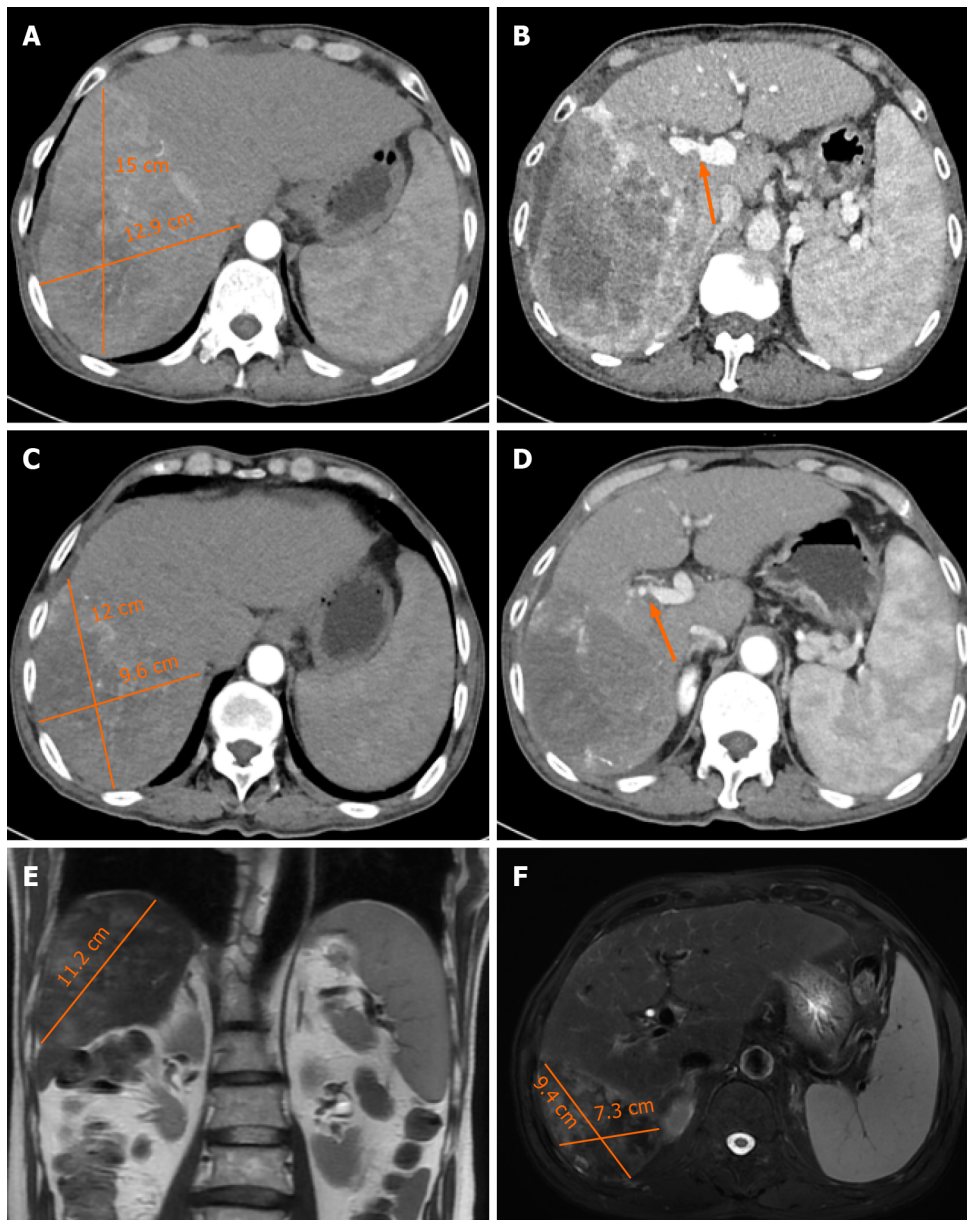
Contrast-enhanced computed tomography and magnetic resonance images of the patient. A: Axial images of the arterial phase before treatment; B: Axial images of the portal phase before treatment; C: Axial images of the arterial phase after 3 months of treatment; D: Axial images of the portal phase after 3 months of treatment; E: Sagittal sectional magnetic resonance image (MRI) images before surgery; F: Cross-sectional MRI images before surgery.
